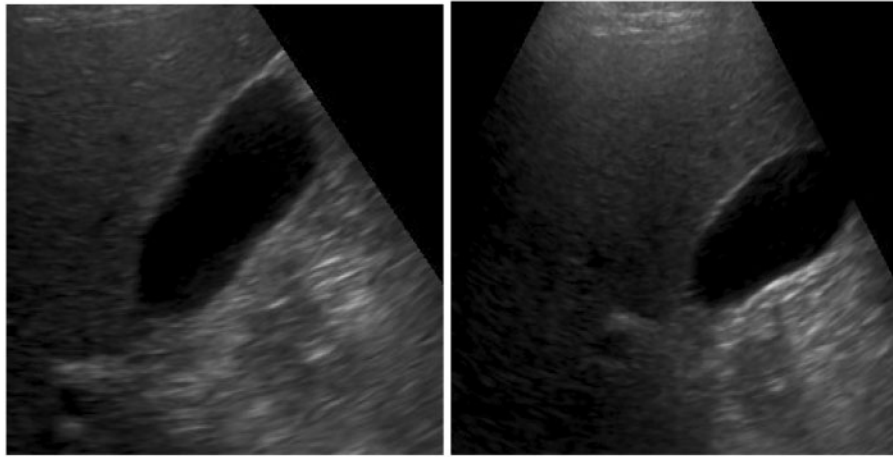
Ultrasound scan of gall bladder.
